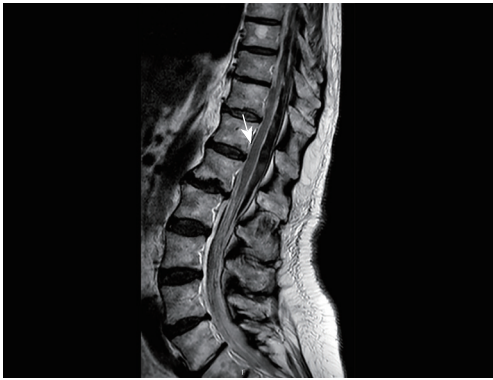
MRI (T2 sequence, sagittal) showing a spinal subarachnoid hemorrhage, with blood from the level of thoracic vertebrae 6 to the sacral and with ventral displacement of the spinal cord without signs of myelopathy. An additional subdural component cannot be ruled out with certainty. No evidence of a vascular malformation or dural fistula as the cause. The arrow indicates the spinal subarachnoid hemorrhage with ventral displacement of the spinal cord. MRI, magnetic resonance imaging.
